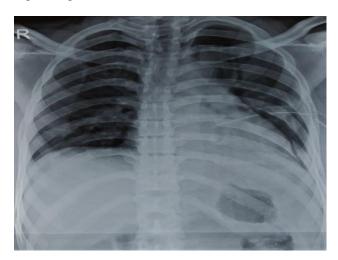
X-ray after 2 weeks, showing adequate lung expansion and gastric shadow in normal position.
